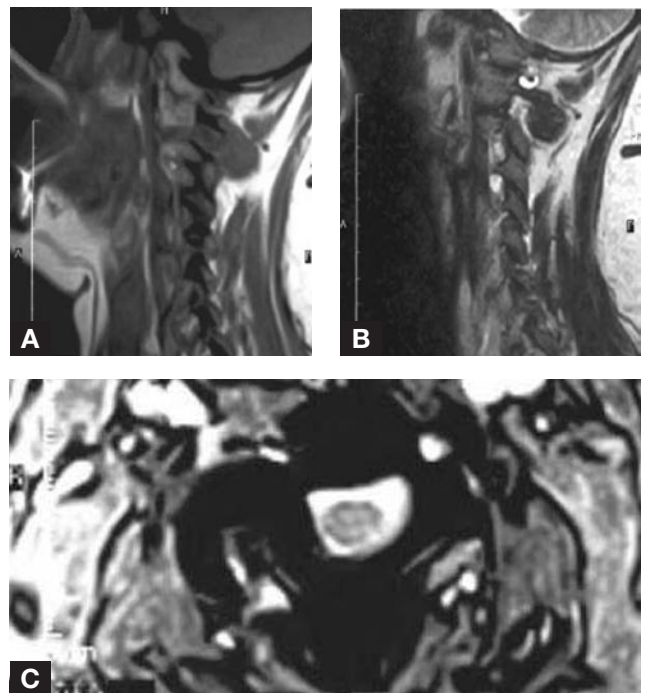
Magnetic resonance imaging (MRI) scans of cervical spine: (A) T₁-weighted sagittal scan shows uniformly low signal intensity lesion encroaching on right C2–C3 facet joint. (B) T₂-weighted sagittal scan shows lesion maintaining low signal intensity. (C) T₂-weighted axial scan shows involvement of right C2–C3 facet joint of low signal intensity lesion. There are no significant impingement into the spinal canal and no abnormal signal in the spinal cord.
